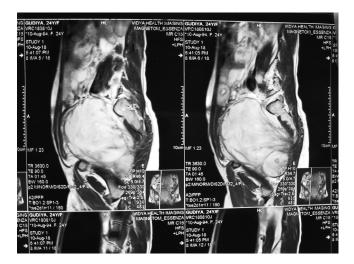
Sagittal section of T2-weighted MRI Pelvis showing a large soft tissue mass in the presacral region. The mass is seen compressing the urinary bladder and uterus.
